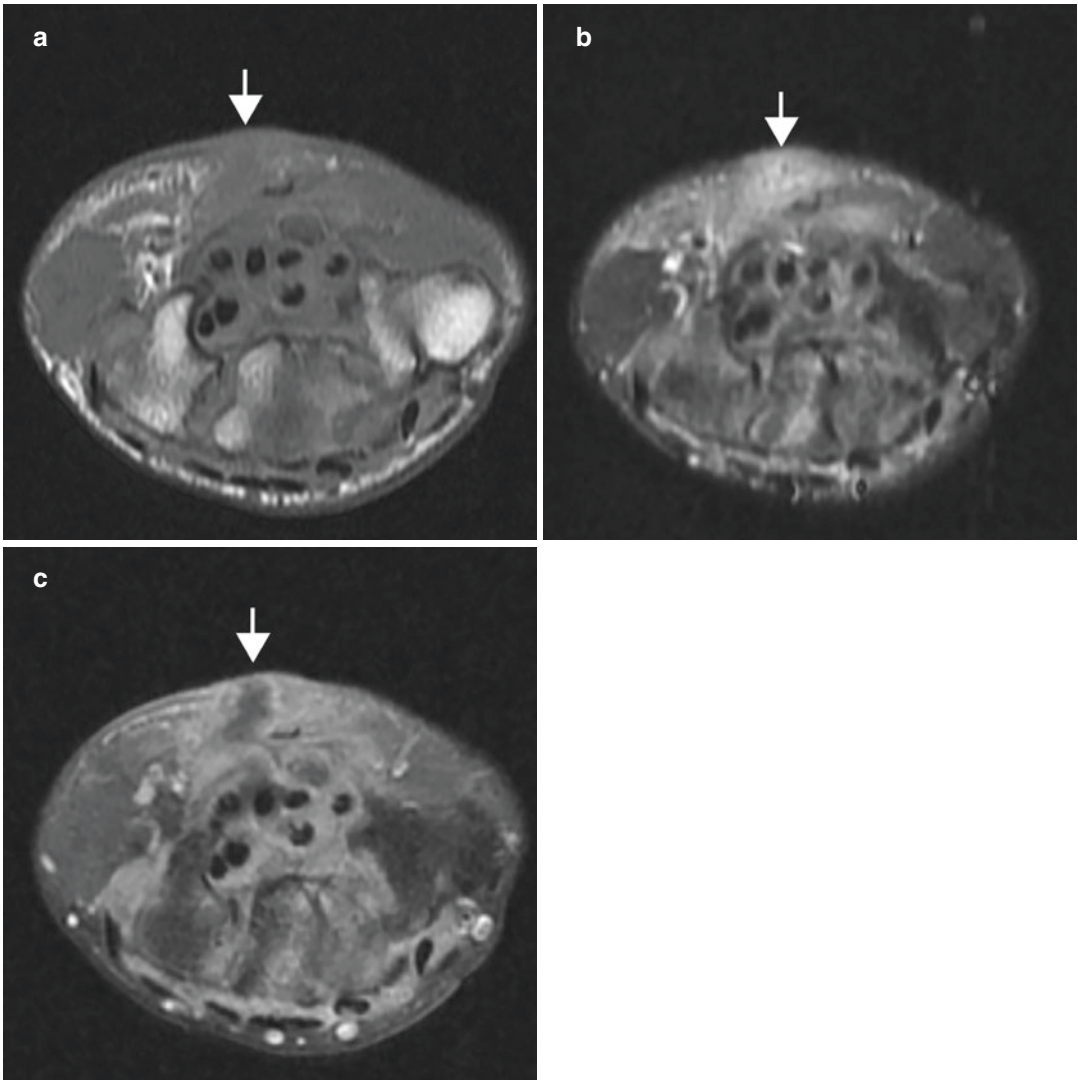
Tuberculous arthritis and tenosynovitis with a sinus tract in a 41-year-old man who had wrist pain and a draining sinus for 6 months. Axial (a) T1-weighted, (b) STIR, and (c) contrast-enhanced fat-suppressed
